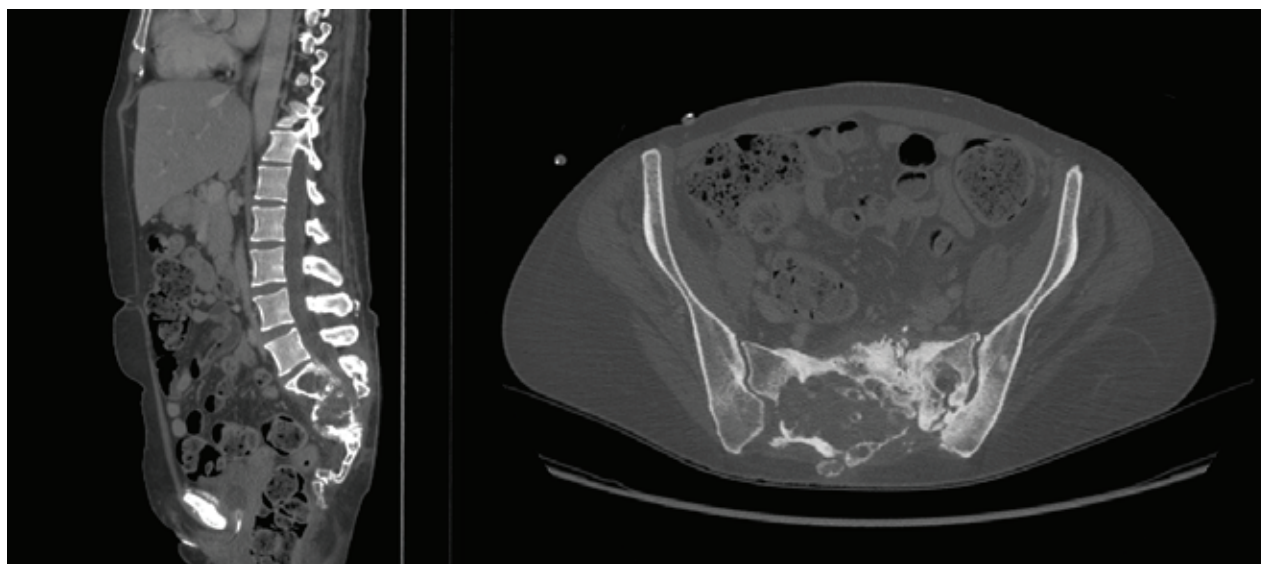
(A, B) The CT images acquired about 6 months after the cryoablation treatment show a picture of disease stability; in fact it is evident that the tumor mass has remained substantially unchanged in size and tomodensitometric characteristics since the last CT evaluation.
